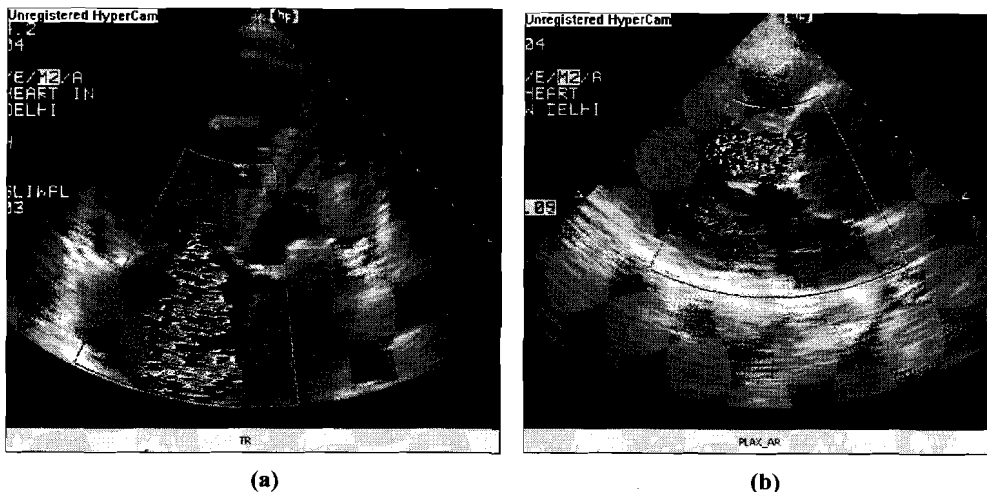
Colour Doppler across tricuspid valve in apical four chamber view in patient with severe TR (a) and across aortic valve (b) in PLAX view in patients with severe AR
